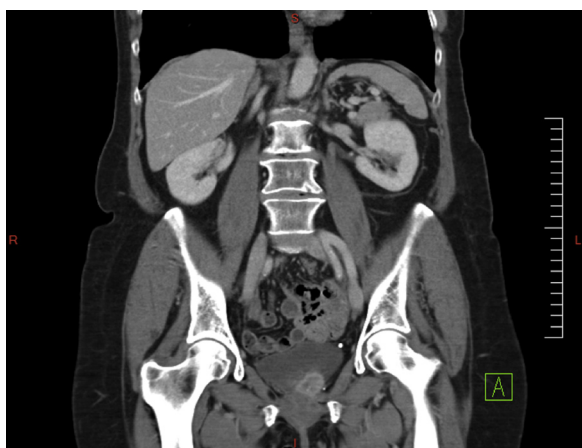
Mass of the left-postero lateral wall of the bladder on CT-scan.
